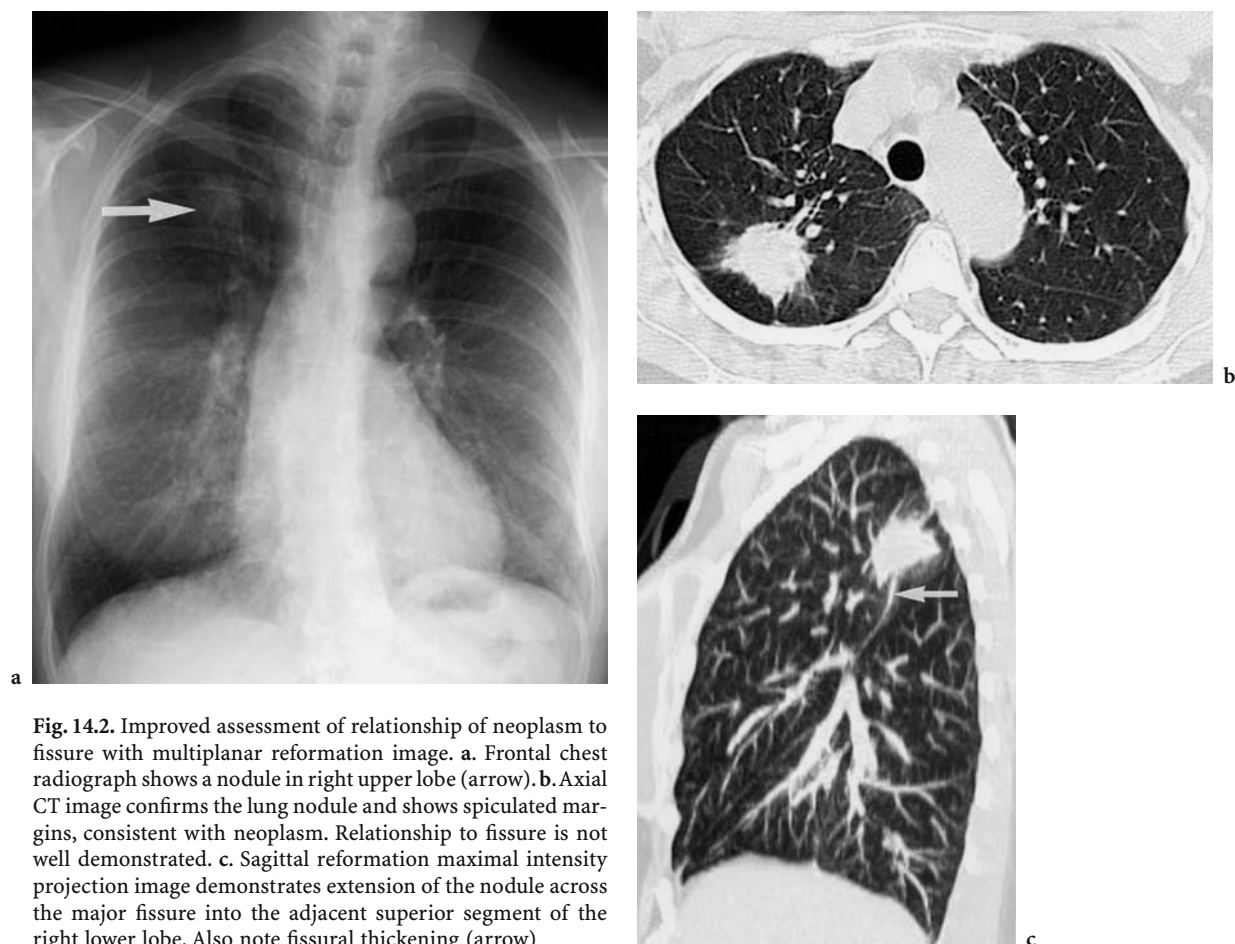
Improved assessment of relationship of neoplasm to fissure with multiplanar reformation image. a. Frontal chest radiograph shows a nodule in right upper lobe (arrow). b. Axial CT image confirms the lung nodule and shows spiculated margins, consistent with neoplasm. Relationship to fissure is not well demonstrated. c. Sagittal reformation maximal intensity projection image demonstrates extension of the nodule across the major fissure into the adjacent superior segment of the right lower lobe. Also note fissural thickening (arrow)
